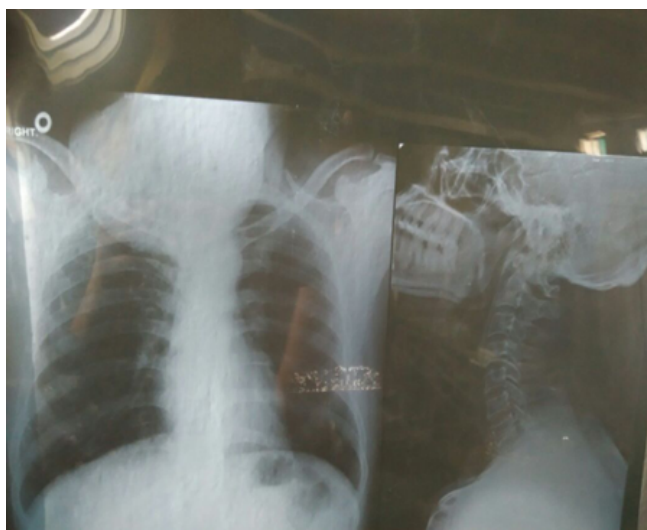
X-ray demonstrating soft tissue shadow without bony involvement.
